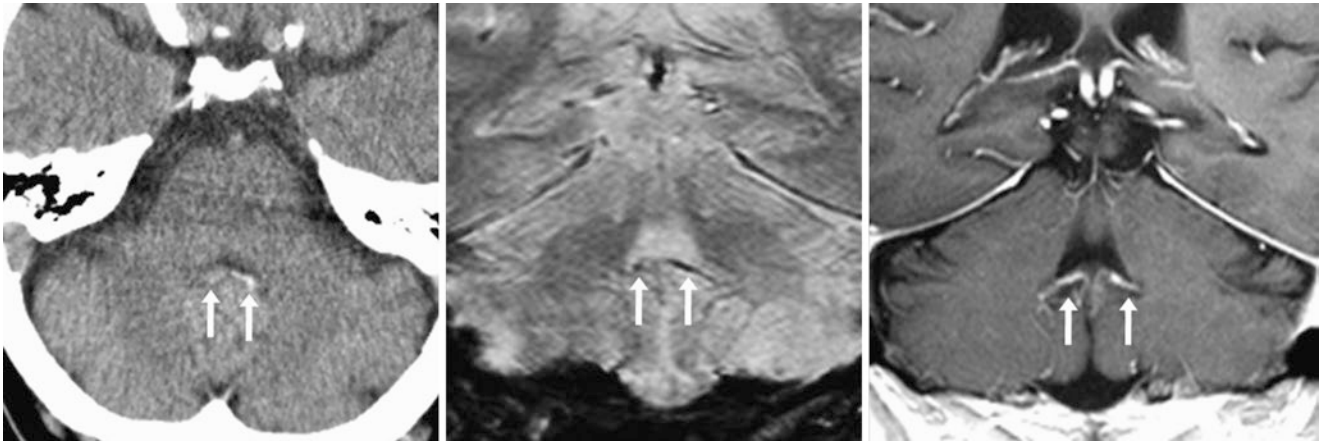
A 67-year-old patient with partially calcified CP (*arrows*) of the fourth ventricle on axial NECT (*left*), mimicking subarachnoid hemorrhage (SAH). A 3 T MRI confirmed that this was CP since there was susceptibility effect from the calcium on coronal GE T2*WI (*middle*), and CP enhanced avidly on coronal postcontrast T1WI (*right*)
